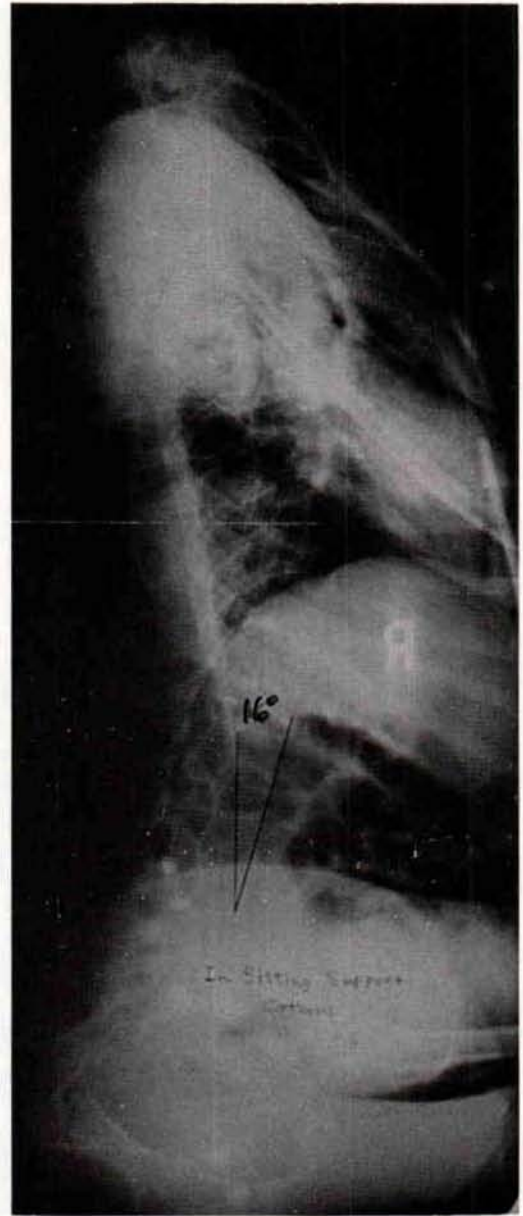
Lateral X-ray of patient shown in Fig. 11 in his Sitting Support Orthosis.
